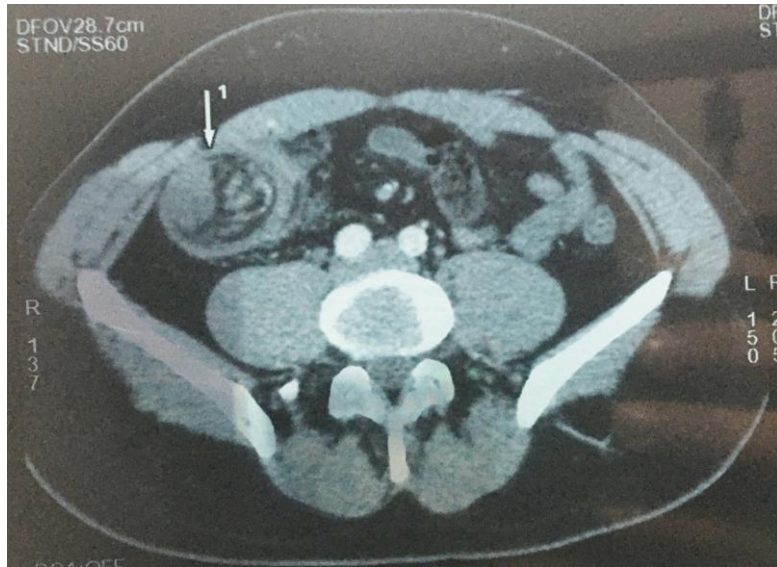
axial CT scan showing the cockade aspect.
